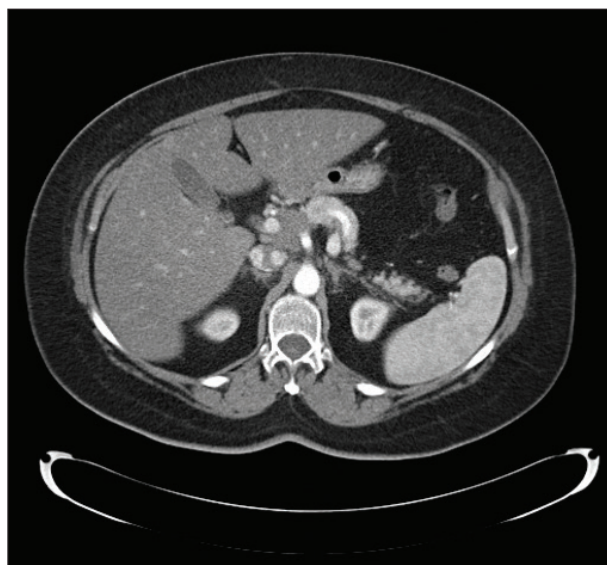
A CT scan showing pancreatic adenocarcinoma.
